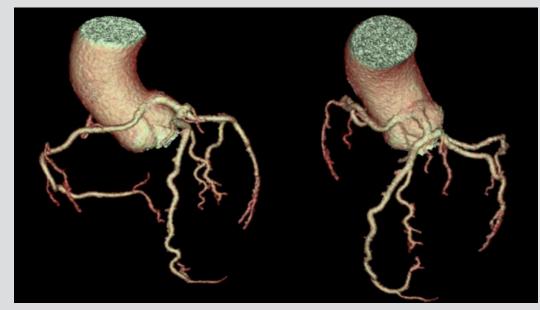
Computed tomography three-dimensional reconstruction showing both the left main and right coronary arteries originating from the left coronary cusp
